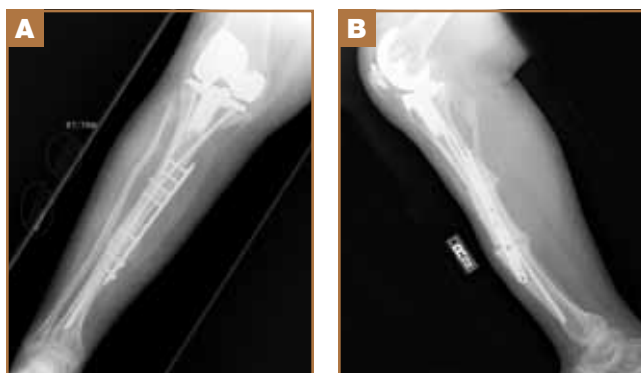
AP (A) and lateral (B) radiographs of the right knee and tibia after TKA and tibial osteotomies demonstrating healing of osteotomy sites.
